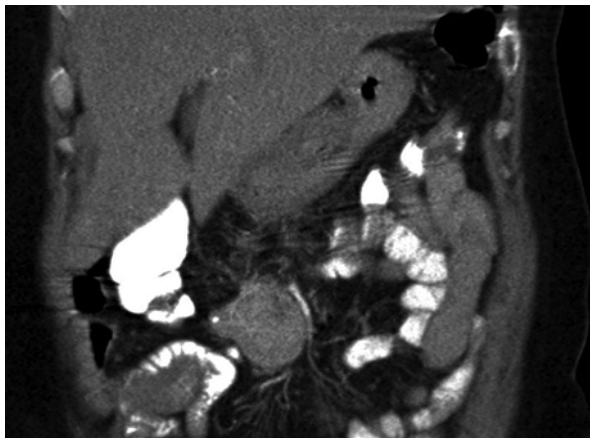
The extension below or above the horizontal duodenum (depicted with coronal CT) is crucial for evaluation of operability of an Si-NET mesenteric metastasis, as this can determine if metastases are regional or located high in the mesenteric root
